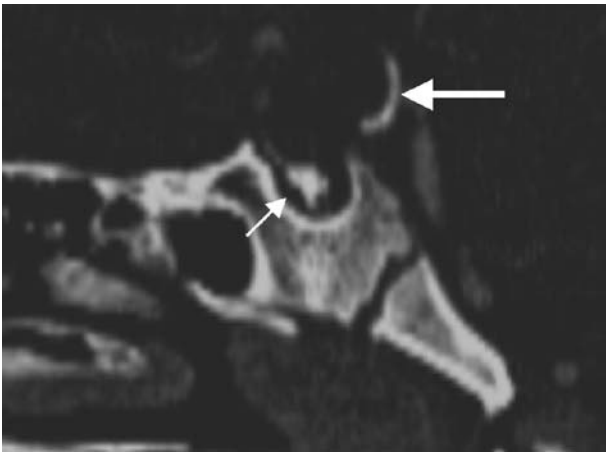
CT: lateral reconstruction showing incomplete pneumatization of the sphenoid bone and thickened sellar floor, intra-sellar calcification (*small arrow*) and calcification of the posterior aspect of the suprasellar capsule of the cyst (*larger arrow*)
